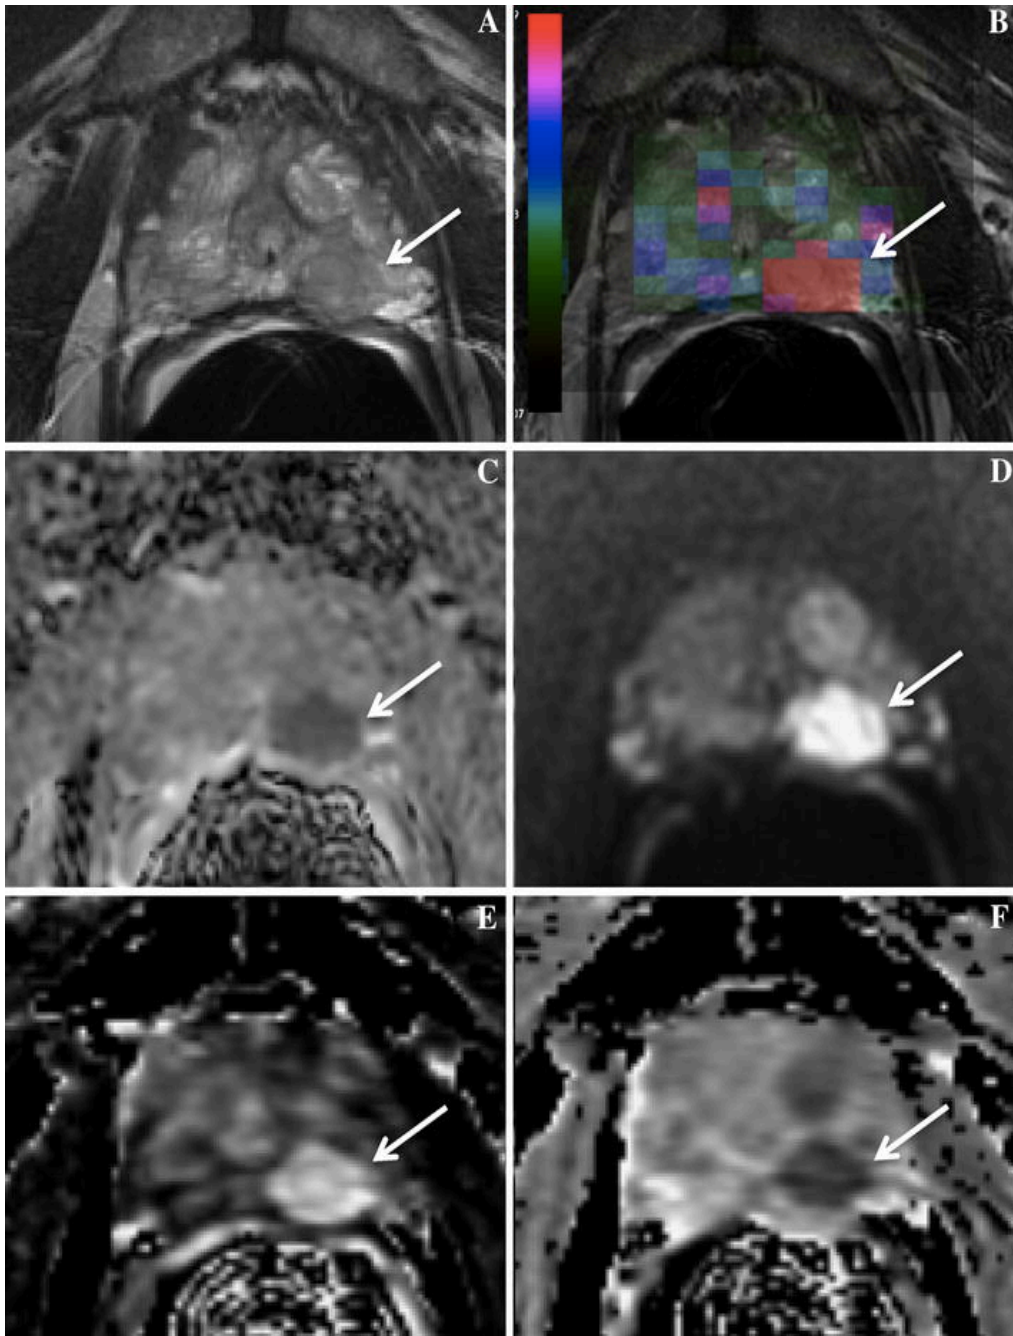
Examples of some of the images acquired as part of mpMRI scan. An untreated 78 year-old man with serum PSA of 9.8 ng/ml showing a a) coil-corrected T2-weighted FSE image, b) MRSI choline metabolite map created in SIVIC², c) rFOV ADC map ($b=0$, 600 sec/mm^2), d) coil-corrected rFOV DWI ($b=1350$ sec/mm^2), and DCE-derived semiquantitative parameters of e) enhancement slope, and f) washout slope. Subsequent TRUS–MRI fusion-guided biopsy revealed a Gleason 4+3 lesion in the left apex. The cancer region is indicated by the arrow.
